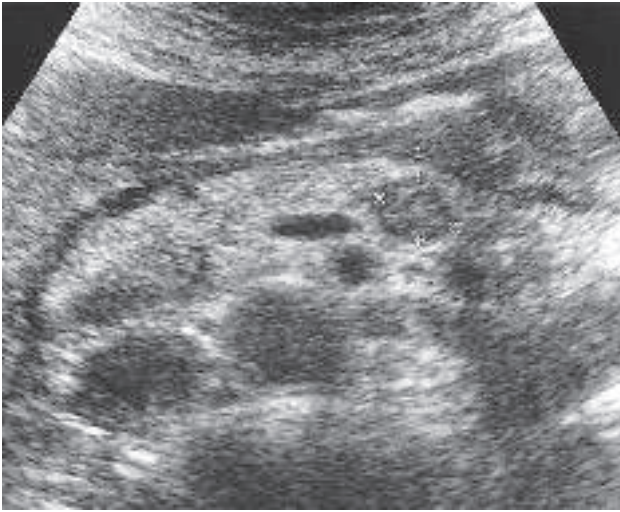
Ultrasound scan of pancreas showing a 1 cm tumour (T) (an insulinoma) at the junction of the head and body of the pancreas. Ao, aorta; Duo, duodenum; IVC, inferior vena cava; P, pancreas; SMA, superior mesenteric artery; SpV, splenic vein.
